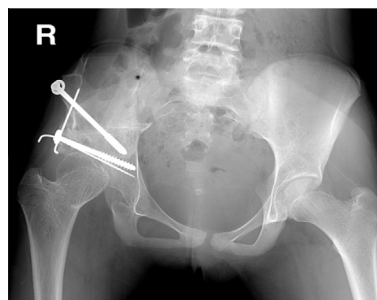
Postoperative standing Anteroposterior radiograph showing center-edge angle of 40° and 100% femoral head coverage.
